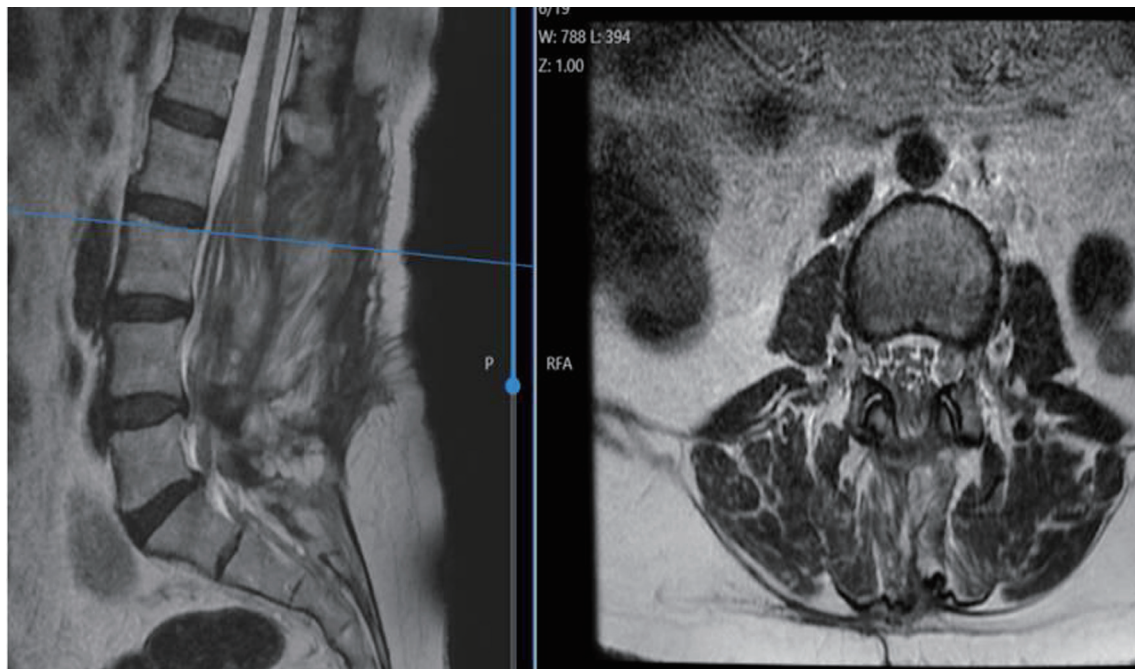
Contrast-enhanced lumbar MRI demonstrating absence of contrast enhancement. MRI: magnetic resonance imaging.
